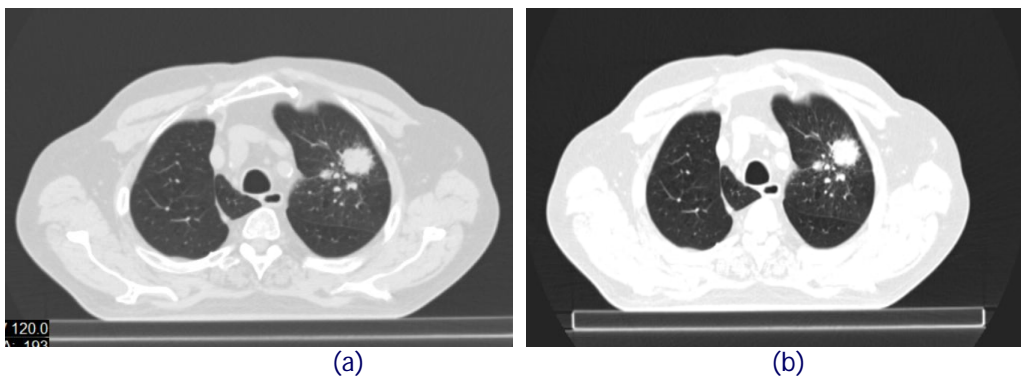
CT-Scan image of a lung cancer patient. (a) original image size of 512 × 512 pixels, (b) image with size of 224 × 224 pixels
